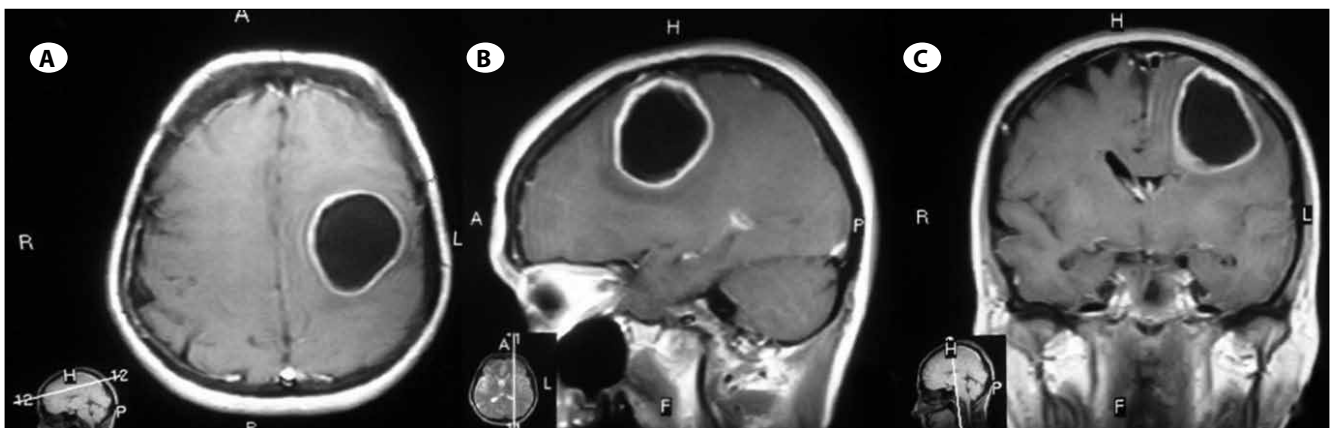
Preoperative T1-weighted contrast enhanced magnetic resonance images confirm intracerebral abscess in A) axial, B) sagittal C) coronal planes.
